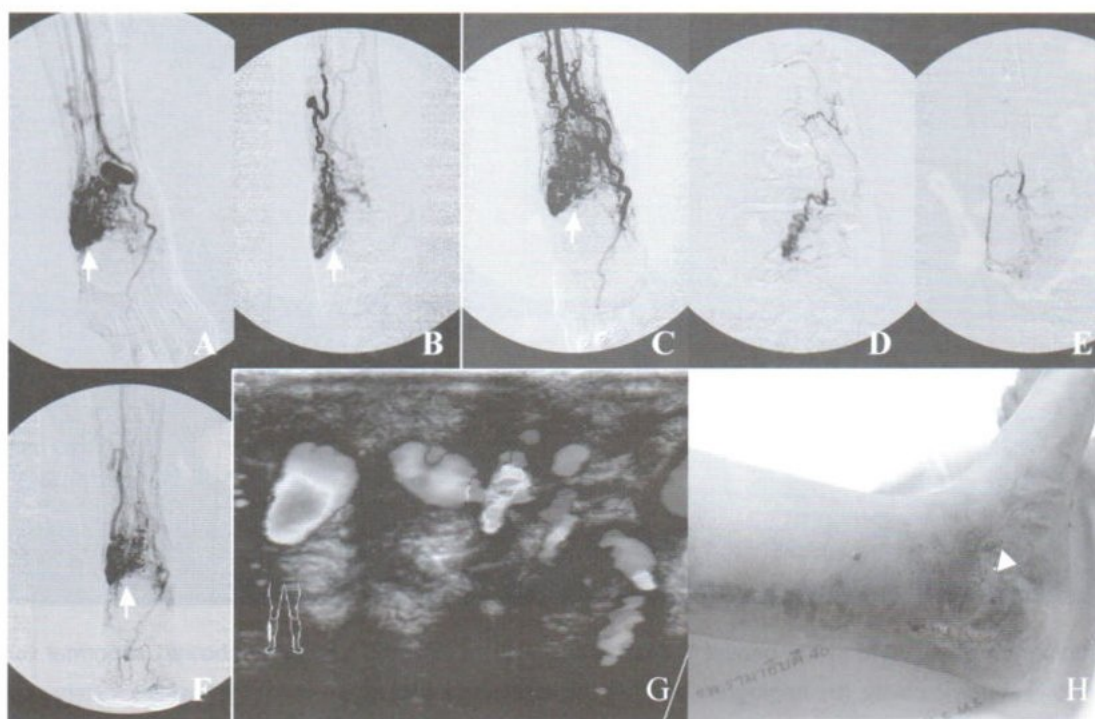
Angiogram of AVM in the patient 8: (A): arterial phase of left foot angiogram showed AVM with nidus. (B): superselective with PVA and glue embolizations. (C): angiogram after three settings of embolization showed 20% devascularization. (D and E): superselective of 4th and 5th embolizations. (F): Post final embolization angiogram showed about 60% devascularization. (G): Doppler US after six years of embolization showed residual AVM. (H): scar after treatment of skin necrosis (arrowhead). Note nidus (arrow).
